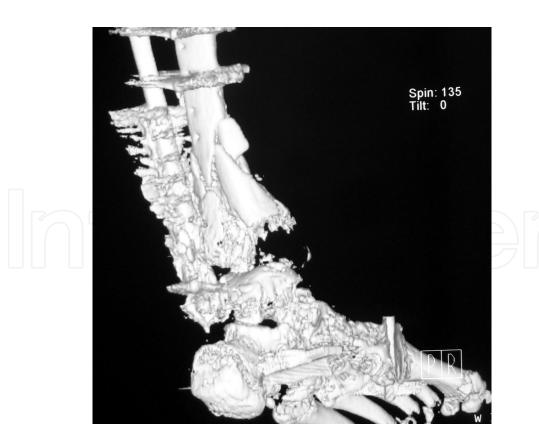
Bone defect of distal tibia CT reconstruction
